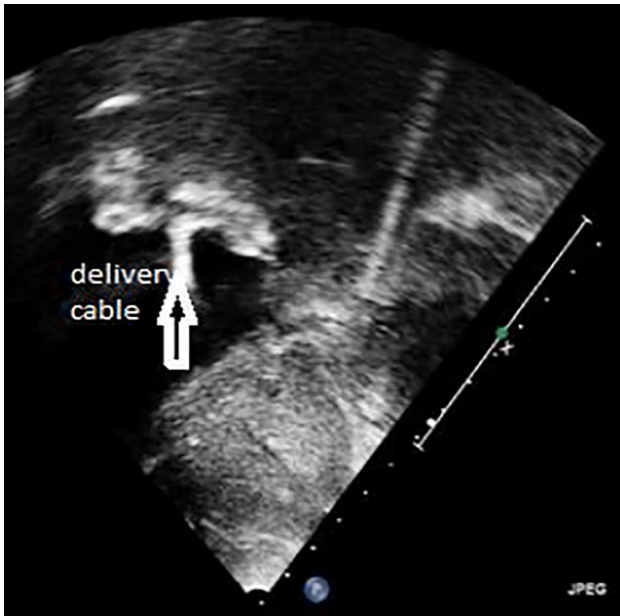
Using transthoracic echo during the procedure, subcostal view showing the Amplatzer device in perfect position with delivery cable before the release of the device
